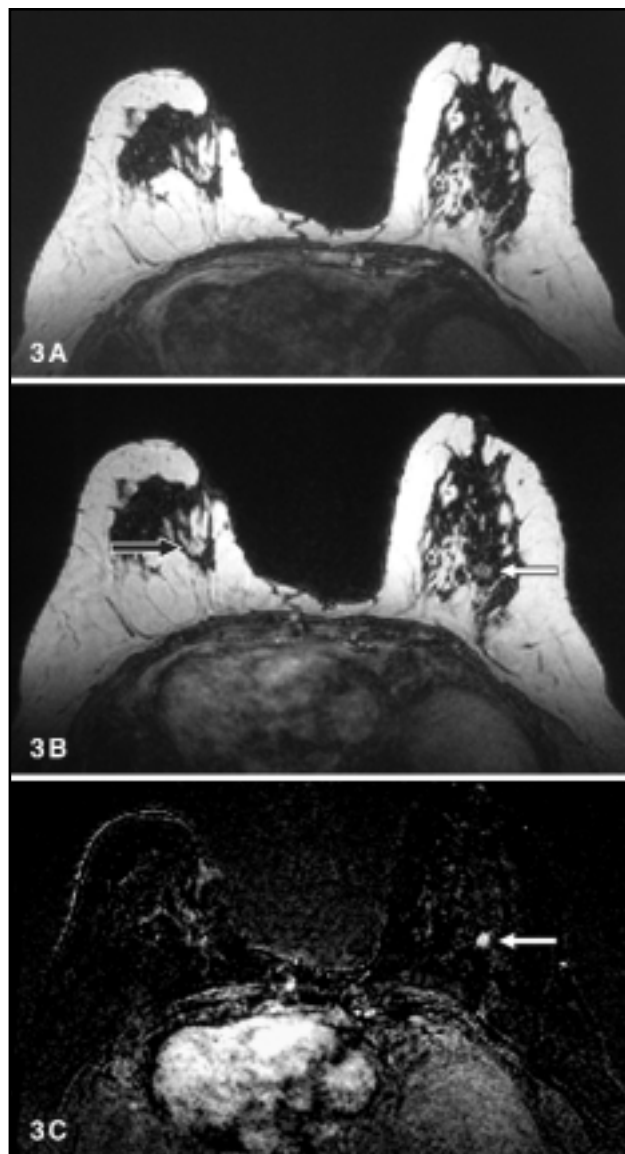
T1-weighted axial breast MR images. (A) Precontrast, (B) post-contrast, and (C) subtraction images of a young woman status post left lumpectomy show mild distortion at the lumpectomy site (black arrow) and a new cancer in the right breast (white arrows).
